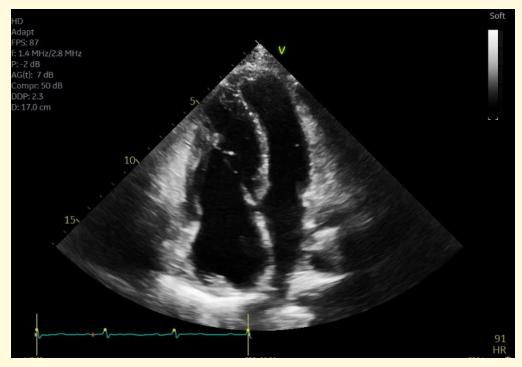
Apical four chamber view with severe RV dilation.
